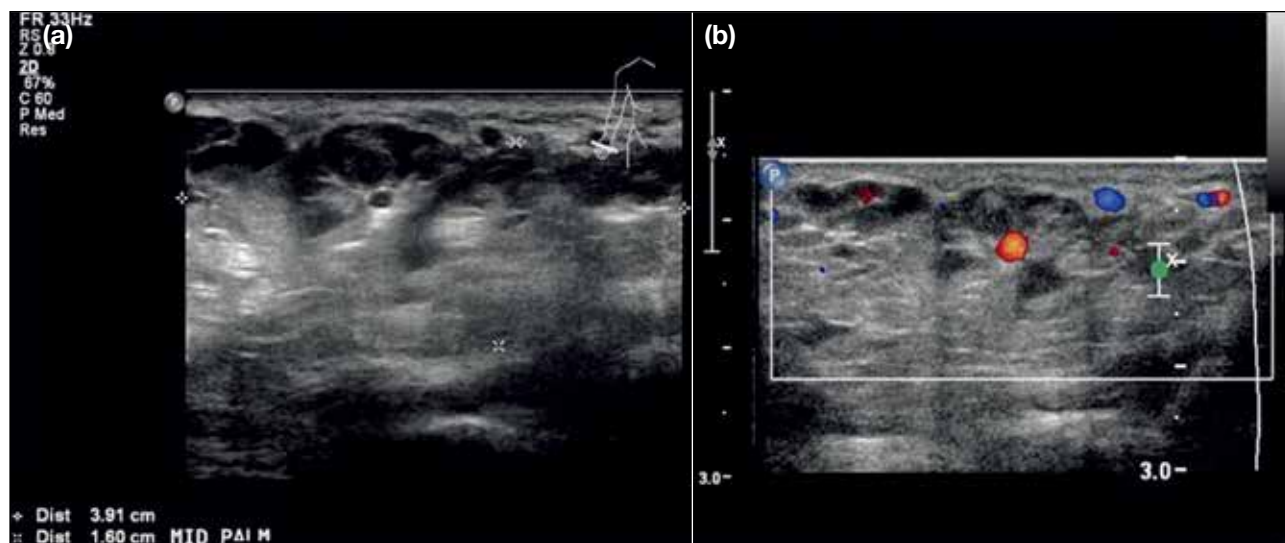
This is the same patient as Figure 9a. Ultrasound image of mid palm in the transverse plane showing an infiltrative multilobulated hypoechoic lesion with low levels of echo, extending from the proximal palm (just distal to the exit of carpal tunnel) down to the metacarpophalangeal joint level (not shown). (b) Multiple loculations with vascularity and venous flow visible on colour Doppler examination.
